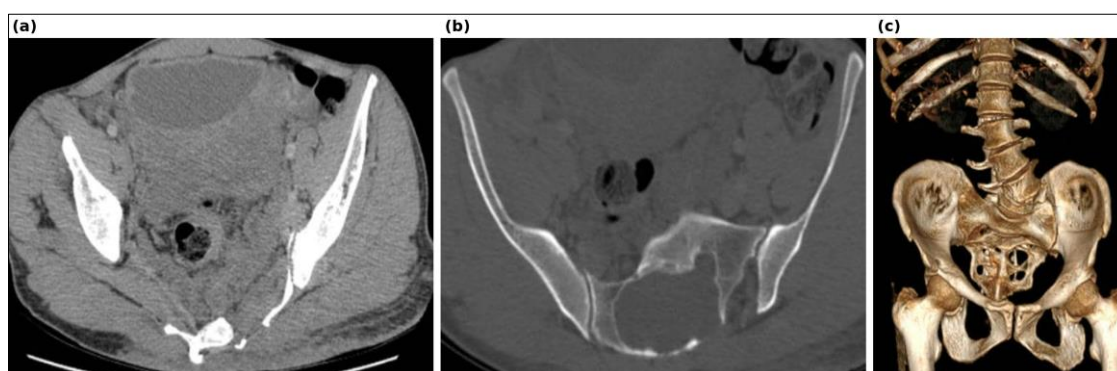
Abdominal CT scan in axial sections in parenchymal window (a) and bone window (b) and 3D reconstruction (c); nodular retroperitoneal masses isodense with minimal enhancement. No cavitation or calcification. Note the scoliosis on 3D reconstruction (c)
